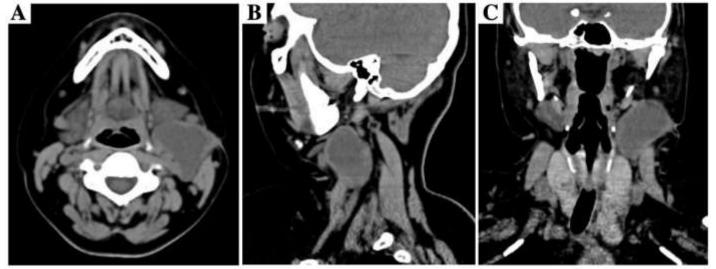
(A) axial CT view demonstrates a well-defined hypodense mass compressing the vital structures medially. (B) sagittal view of the CT demonstrates the superiorinferior enlargement of the cyst. (C) coronal view of the CT demonstrates the depth of extension of the cyst.
